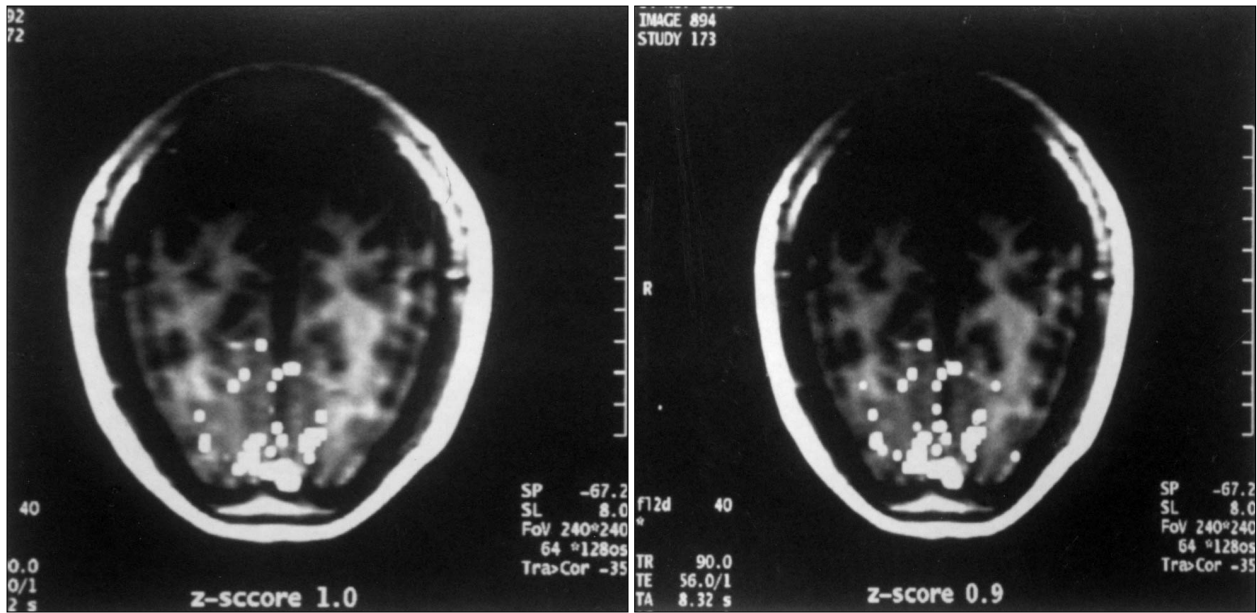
Functional magnetic resonance images demonstrating equal distribution of visual cortex on bilateral occipital area.
